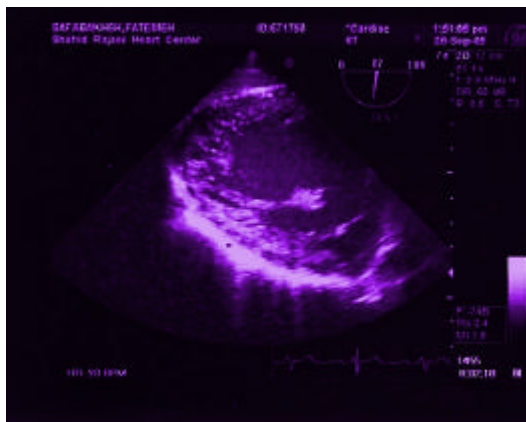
Transgastric transesophageal view showed multiple prominent trabeculations with deep intertrabecular recesses in posterior apical region
